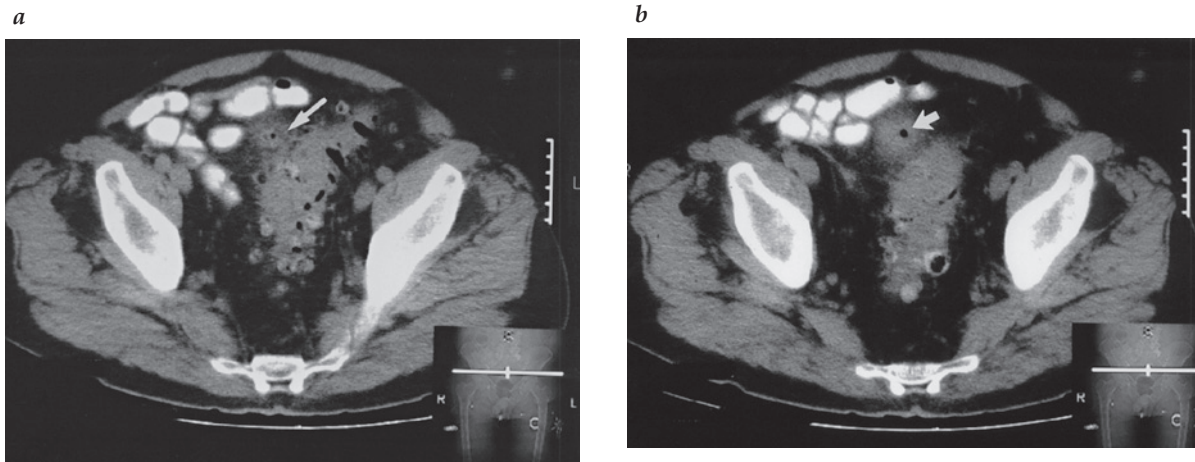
(a) Computed tomographic (CT) scan in a patient with a colovesical fistula shows air in the thickened tract (arrow) adjacent to the sigmoid colon. (b) CT scan through an adjacent plane shows air in the bladder (arrow) as a result of the fistula. No contrast is present in the bladder.
